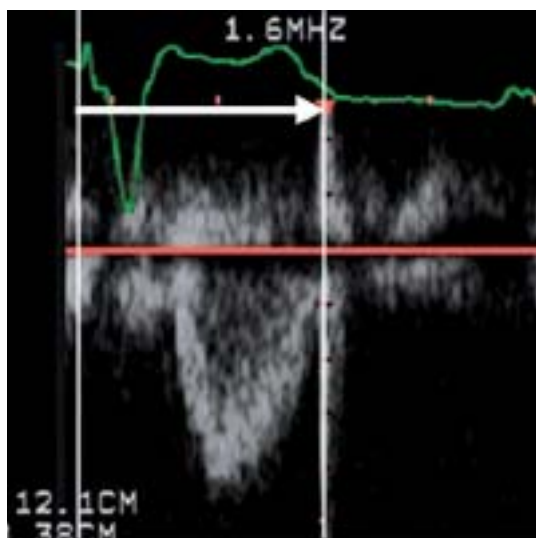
The time from onset of the QRS wave to the end of left ventricular ejection assessed by pulsed wave Doppler
